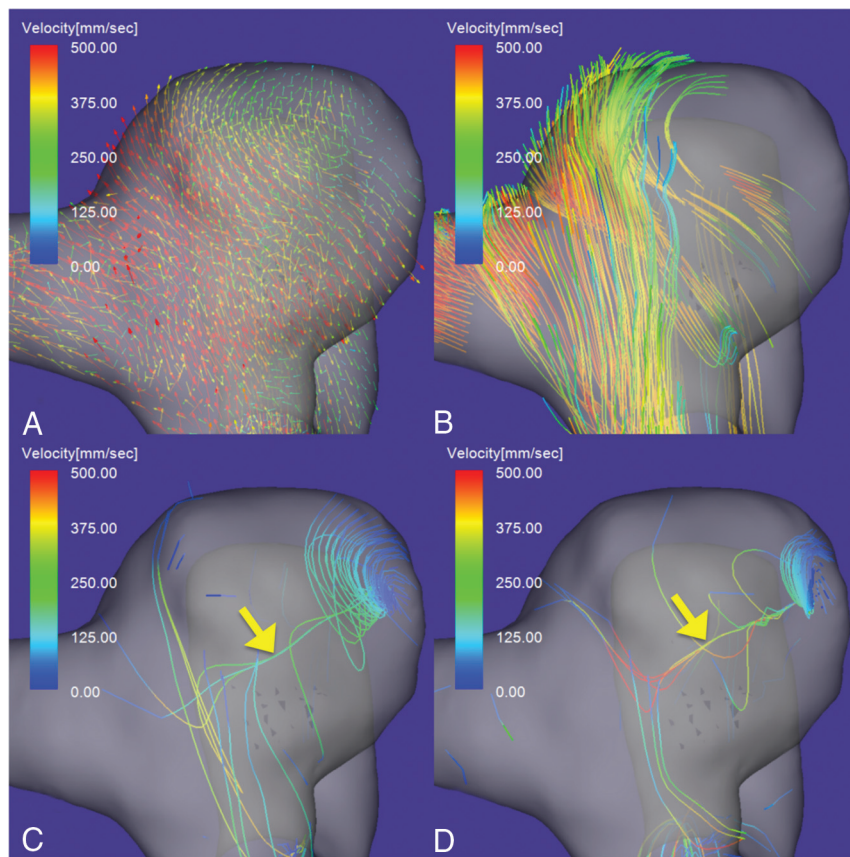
4D flow MR images of an unruptured aneurysm on the paraclinoid segment of the right ICA. *A*, Flow vector map. *B*, The inflow jet is visualized as a layer of streamlines with high velocities. A single stable vortex core (yellow arrow) is visualized in the diastolic (*C*) and systolic (*D*) phases of the cardiac cycle. The vortex core is visualized as a bundle of streamlines with velocities below 7% (*C*) and 10% (*D*) of the maximum inflow velocity. The aneurysm flow pattern is simple and stable.
